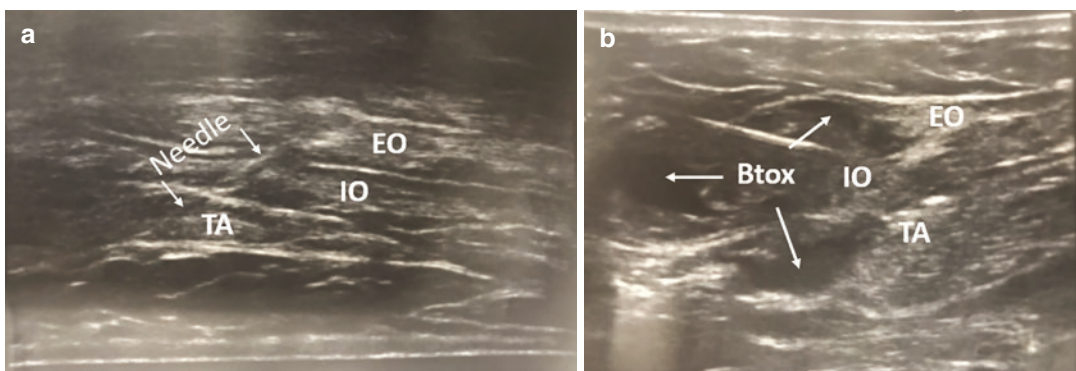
Ultrasound scan of the lateral abdominal wall showing the external oblique (EO), internal oblique (IO), and the transversus abdominis (TA) muscles, before (a)
